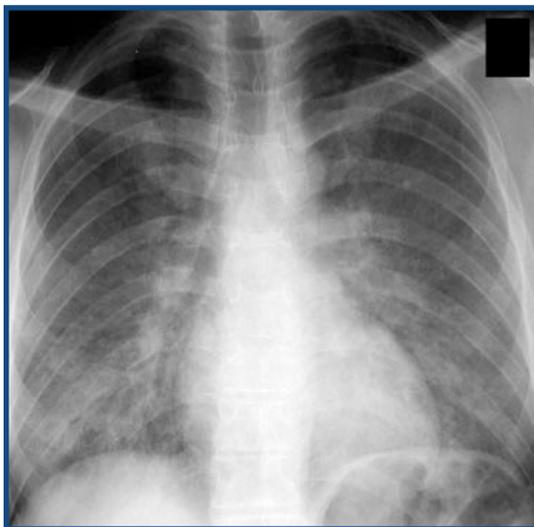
Chest radiograph showing *Pneumocystis carinii* pneumonia in an AIDS patient. Note that the bilateral lower lobe involvement
